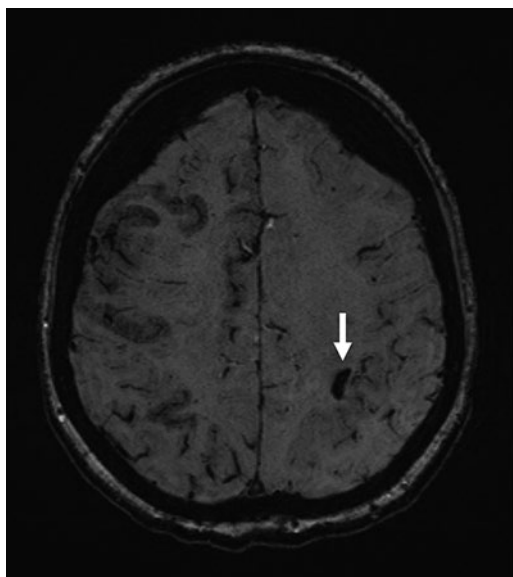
Magnetic resonance imaging scan of the brain (susceptibility weighted imaging) axial at the initial presentation of a woman showing a single juxtacortical haemorrhage located in the parietal lobe of the left hemisphere (arrow). The patient also had sulcal subarachnoid haemorrhage, especially in the right hemisphere.
